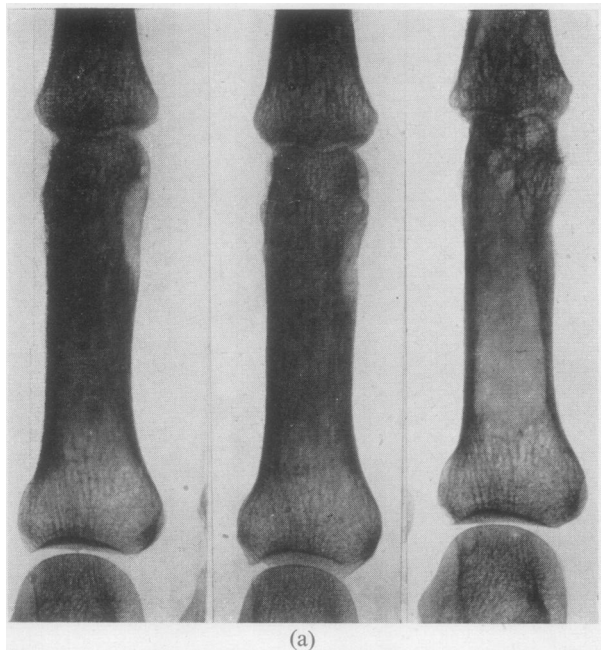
Case 1. Radiographs showing changes in the third (a) and fifth (b) proximal phalangeal heads right hand (compare Fig. 1 (b)). Note progression of lesions from Feb. 8, 1943 (left), to May 15, 1943, and July 20, 1945 (right).
